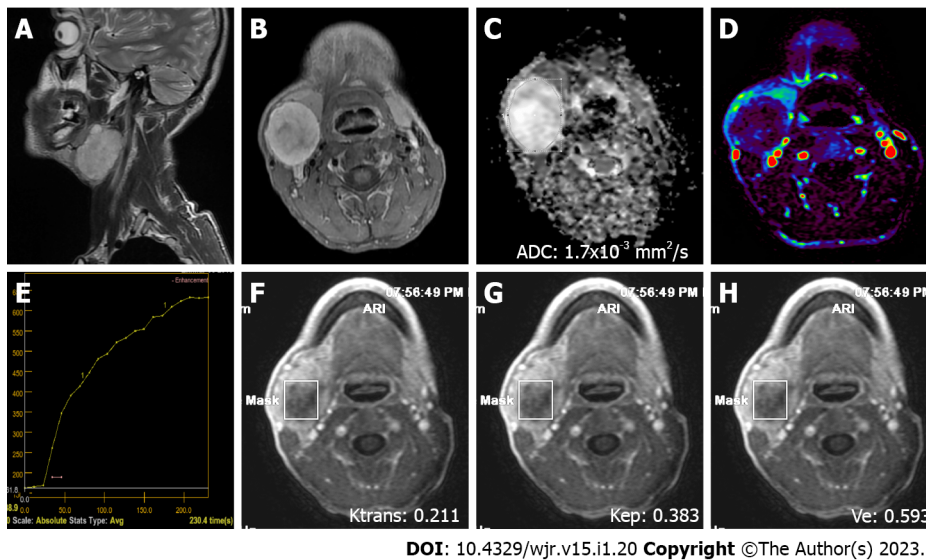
A 38-year-old male patient with a pleomorphic adenoma in the right submandibular gland. A: On sagittal plane T2-weighted image, a hyperintense (compared to the gland), smooth, slightly lobule-contoured mass is observed; B: On contrast-enhanced axial plane T1-weighted image, intense contrast-enhancement is observed in the mass; C: The mass is hyperintense on the apparent diffusion coefficient map due to facilitated diffusion (ADC value: $1.7 \times 10^{-3} \text{ mm}^2/\text{s}$); D: The mass is hypoperfused on color coded perfusion image; E: The tumor has type A time intensity curve; F, G, and H: K_{trans} , K_{ep} , and V_e values on quantitative perfusion images were 0.211 min^{-1} , 0.383 min^{-1} , and 0.593, respectively. ADC: Apparent diffusion coefficient.
